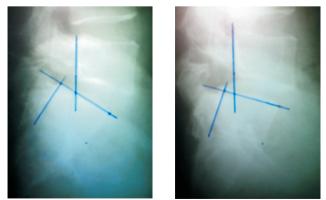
ray L-S (pre-intervention) X-ray L-S (post-intervention)
